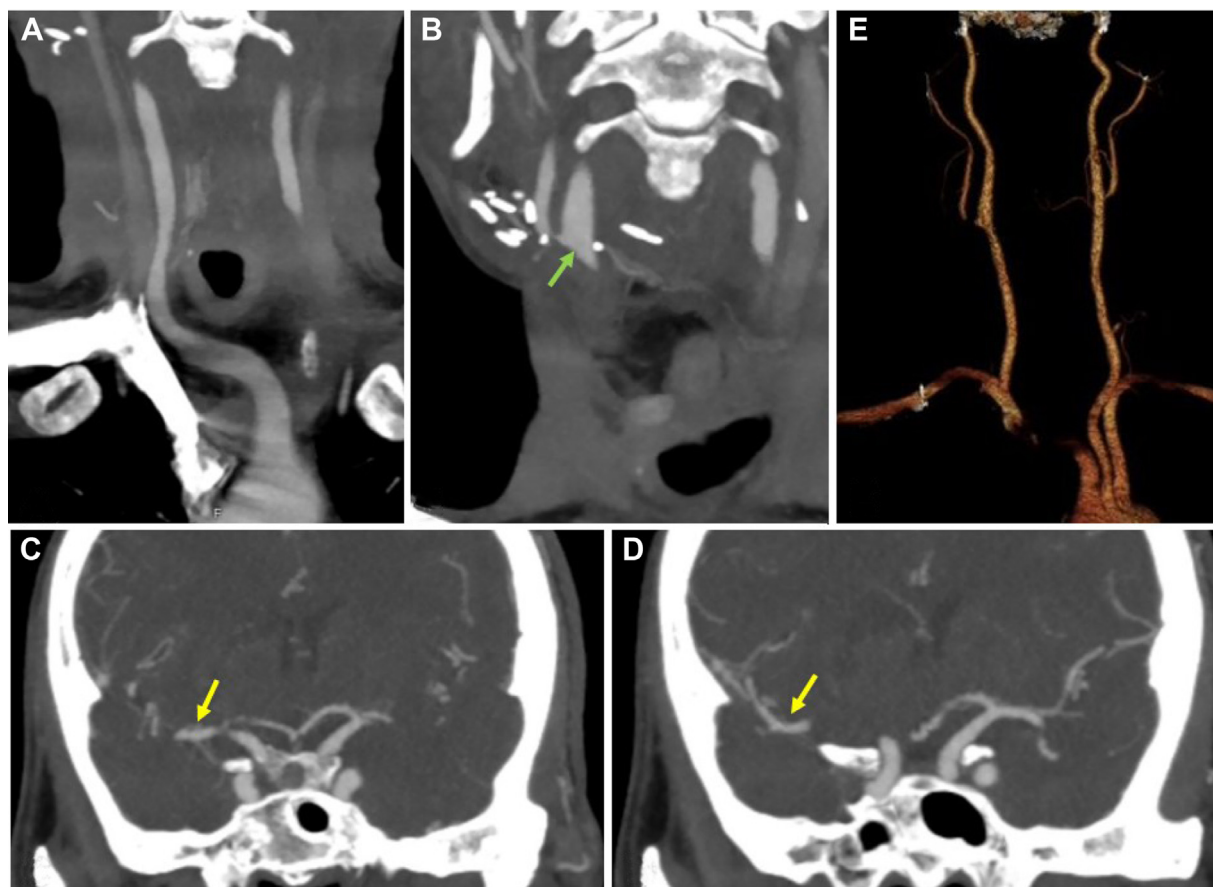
Follow-up computed tomography angiogram (A-D) and three-dimensional reconstruction (E) 2 weeks after the initial stroke presentation with evidence of decreased thrombotic burden and improved patency of the right carotid artery system and right middle cerebral artery (MCA; yellow arrow). The green arrow identifies a patent right carotid bifurcation. C and D, Images showing patency along a previously occluded distal M1 branch of the MCA.
